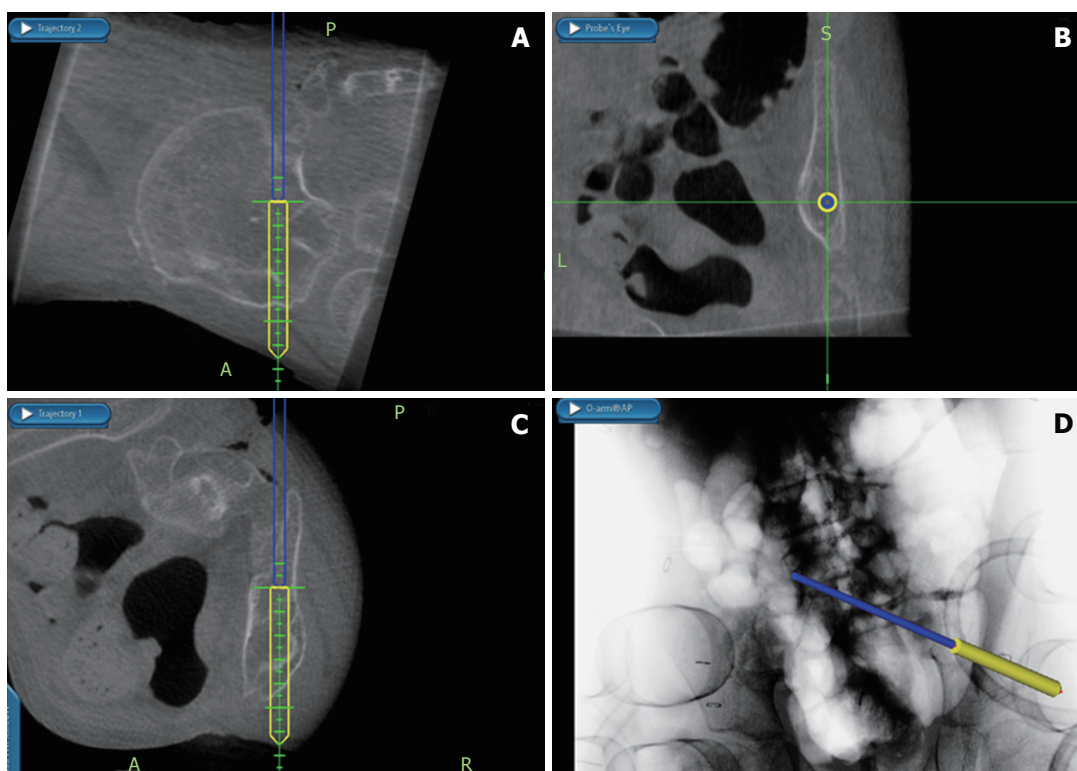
Intra-operative navigation screens depicting a safe trajectory for the S2-alar-iliac technique pelvic screw. A: Sagittal; B: Coronal; C: Axial; D: Anterior-posterior radiograph showing current position of navigation probe.
